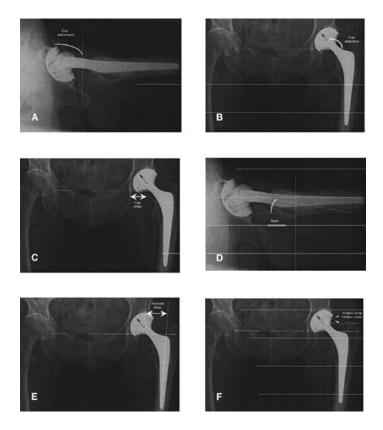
An x-ray with different implant positioning measurement examples. From original caption: (A) Anteversion angle of the acetabular cup. (B) Abduction angle of the acetabular cup. (C) Offset of the cup. (D) Anteversion angle of the stem. (E) Offset of the stem. (F) Height of the hip rotation center [36]. Reproduced with permission from Elsevier. Copyright © 2002 Published by Elsevier Inc.
